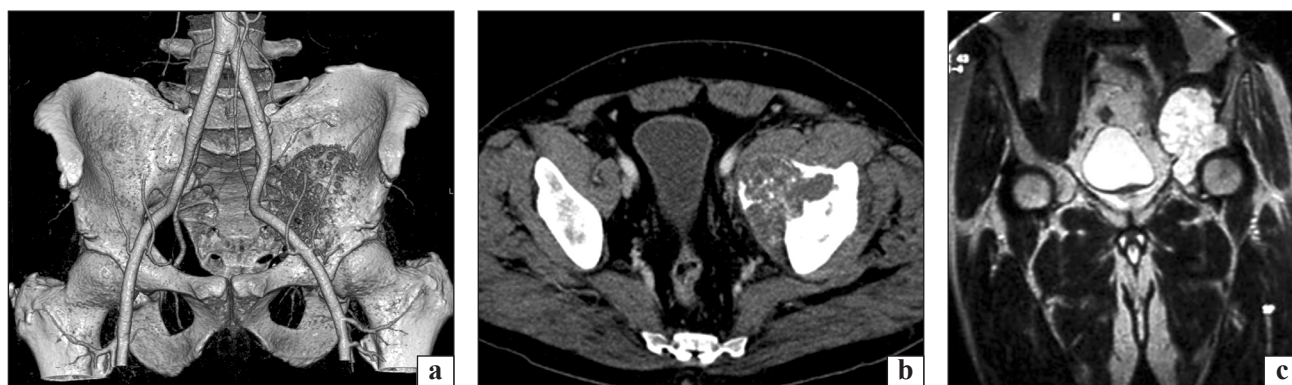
CT 3D reconstruction highlighting the presence of a solid mass with well-defined sinuous margins, transverse diameter of 5.7 cm and cranio-caudal diameter of 9 cm, involving the acetabular area (a); CT scan (b) and MRI showing the expansive characteristics of the mass and its extensive invasion of the adjacent soft tissues (c)
